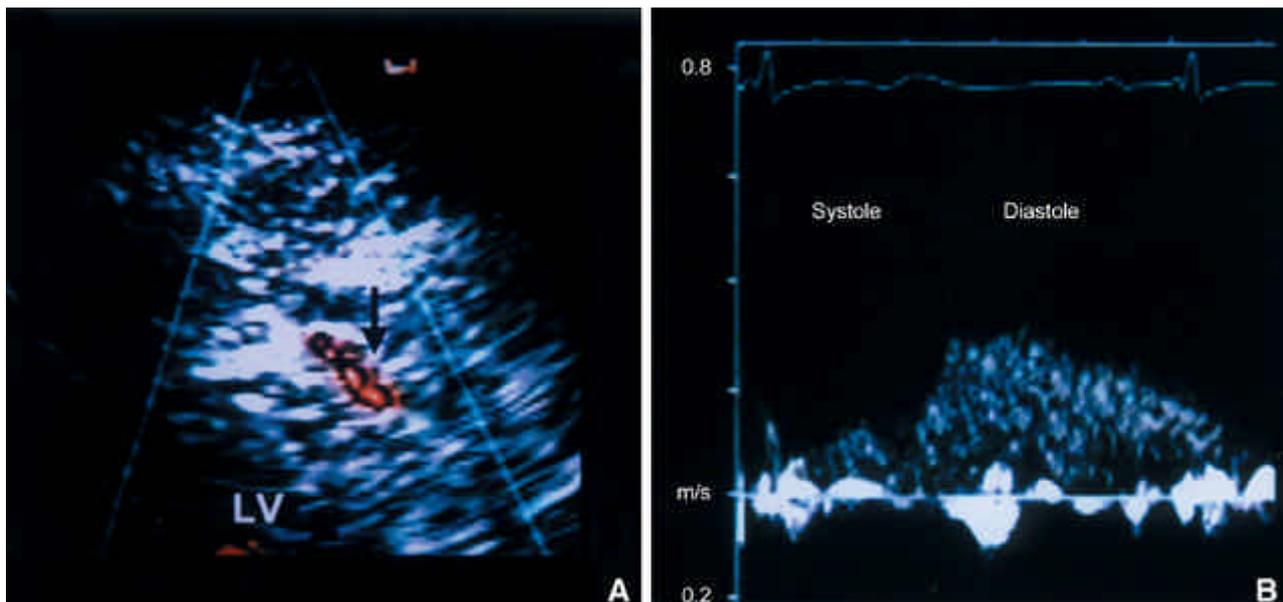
A: Transthoracic color Doppler echocardiography shows blood flow of distal portion of the left anterior descending artery (LAD) in anterior interventricular groove (arrow). B: Blood flow in the distal LAD exhibits a characteristic biphasic coronary flow pattern, consisting of systolic and diastolic phases with higher velocity during diastole. LV, left ventricle.
